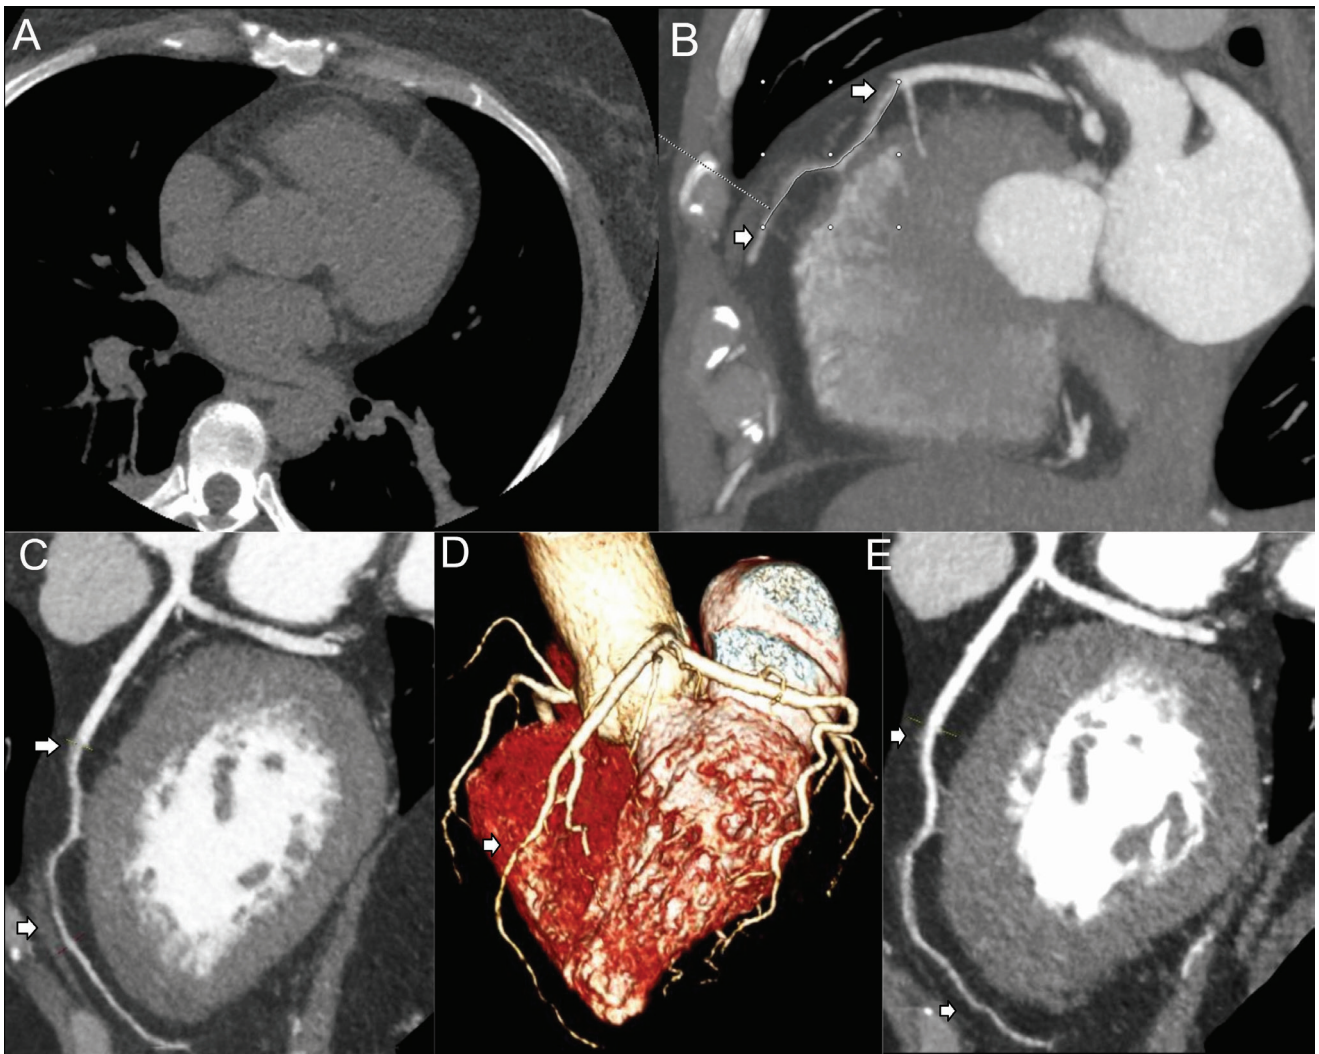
A) Computed tomography angiography – no contrasted acquisition images show absence of any coronary calcification. B) and C) coronary computed tomography angiography – sagittal view shows diffuse spontaneous coronary dissection (SCAD) in the mid and distal segment of left anterior descending artery (LAD) (white arrows), and D) volumetric reconstruction of the heart and coronary arteries, where LAD SCAD is clearly seen (white arrow). E) curved multiplanar reconstruction obtained in a second CCTA show LAD trajectory, with SCAD extension (white arrows).
